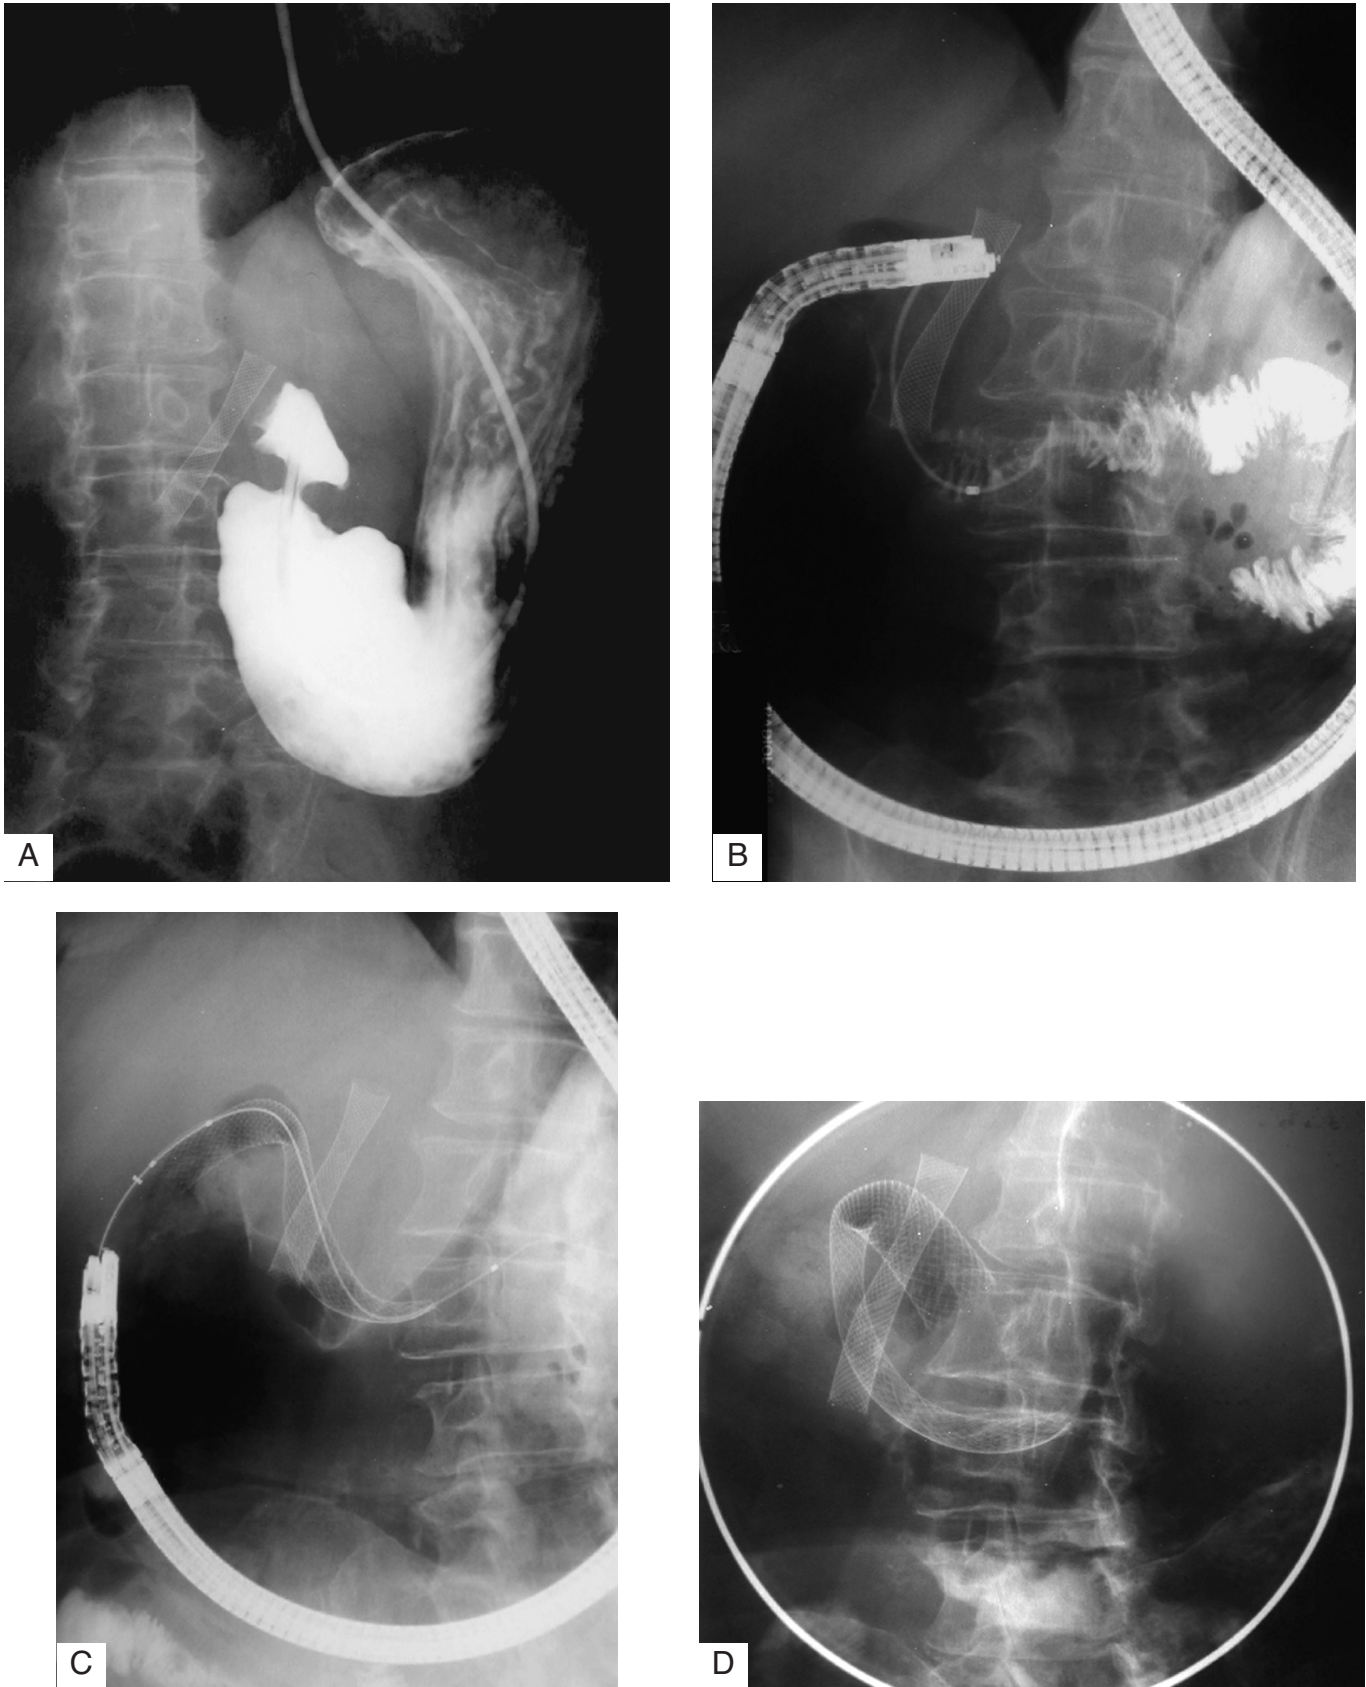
(A) patient affected with pancreatic cancer, previously treated with biliary metallic stent. The x-ray examination shows the duodenal stenosis; (B) x-ray evaluation of duodenal stenosis by means of contrastography through a catheter endoscopically inserted; (C) opening of the duodenal stent on the guide wire; (D) completely expanded stent after removal of the release system and of the endoscope.
